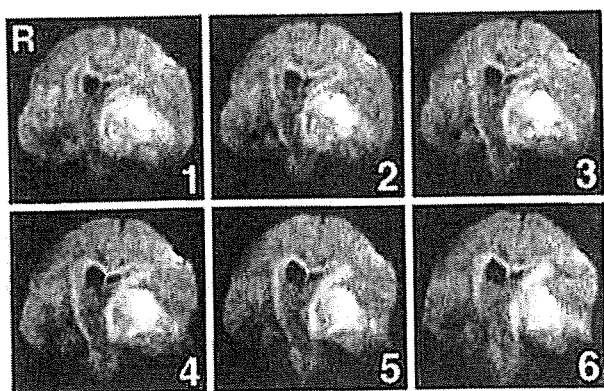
Serial coronal intraoperative diffusion-weighted magnetic resonance images (from 1 to 6) at 3-mm slice intervals before resection of the left frontotemporal glioblastoma. The white matter bundle containing the pyramidal tract is strongly compressed by the tumor and shifted inwards. The spatial interrelationship between the neoplasm and the tract is clearly demonstrated.
